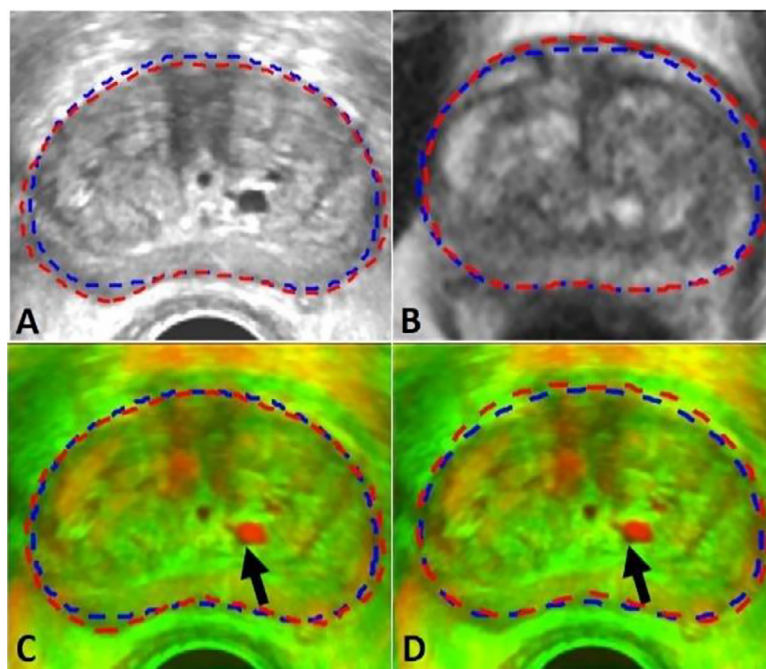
A-B: Manual contours and automatic contours on TRUS and MR images, respectively. Manual contours are shown in red and automatic contours are shown in blue. C-D: Fused images of registration results using manual contours and automatic contours, respectively.
